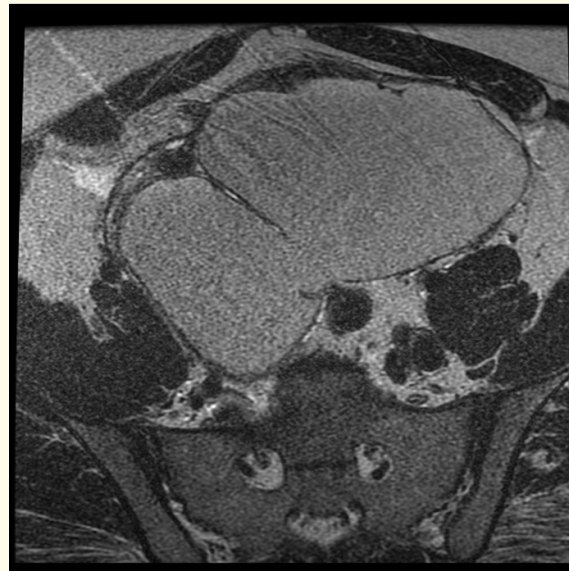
MRI T2 sequence of left ovarian mass.
